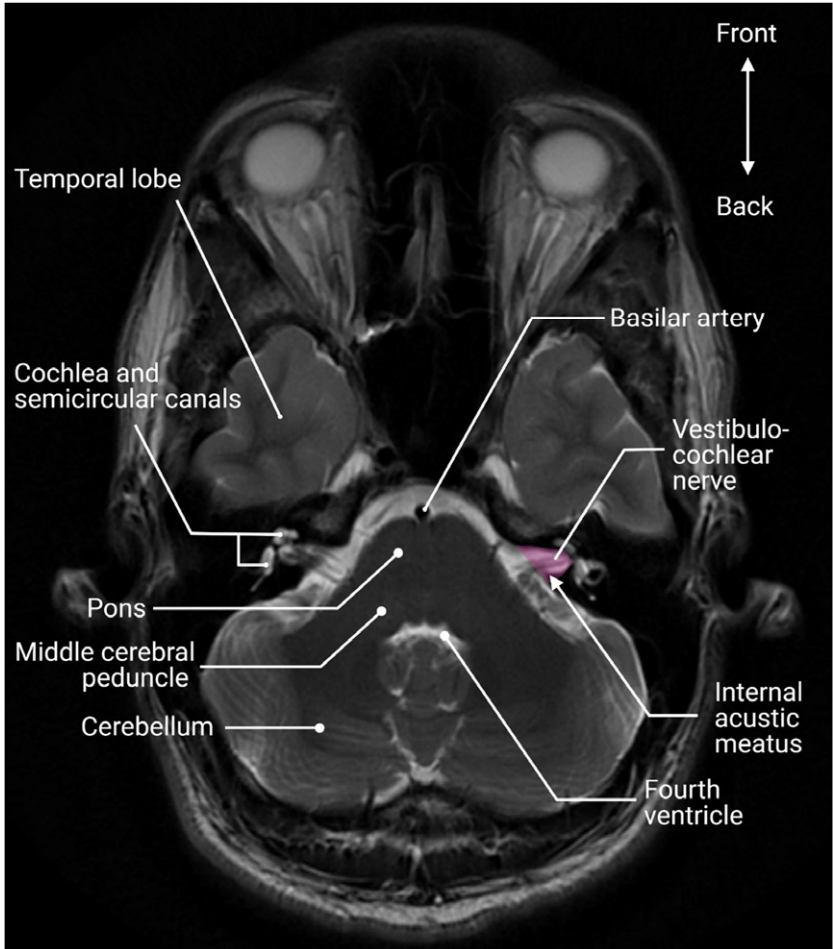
demonstrating normal anatomy of a patient without VS, T2 MRI sequence without contrast. On a T2 image like this, water is white and bone is black. White structures close to pons consist of cerebrospinal fluid (CSF) in basal cisterns. A VS growing in the IAC will eventually bulge into the cleft of CSF separating the pons from the IAC, and eventually compress the pons. This can in turn compress the fourth ventricle, causing obstructive hydrocephalus. Note that the facial nerve (VII) runs close to the vestibulocochlear nerve in the IAC.
